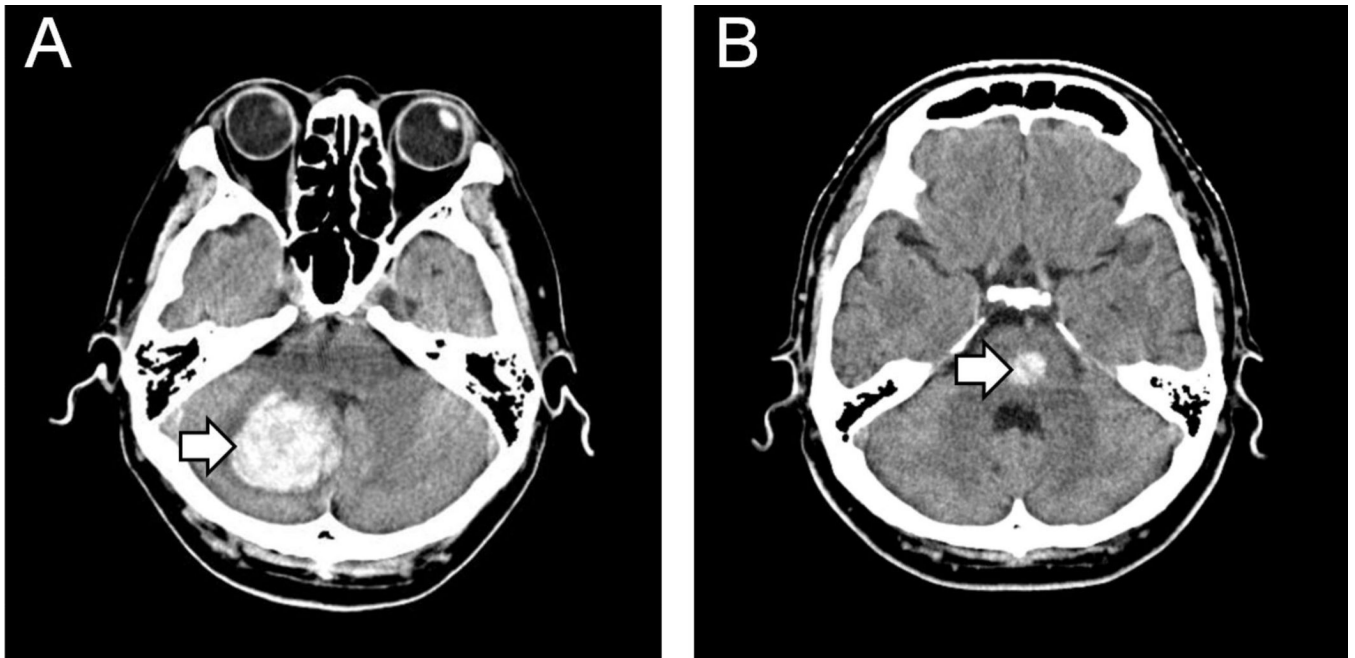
Images showing computed tomography of the head. The lesion foci (white arrows) represent infratentorial hemorrhage in the Human cerebellum (A), and the pons (B).
